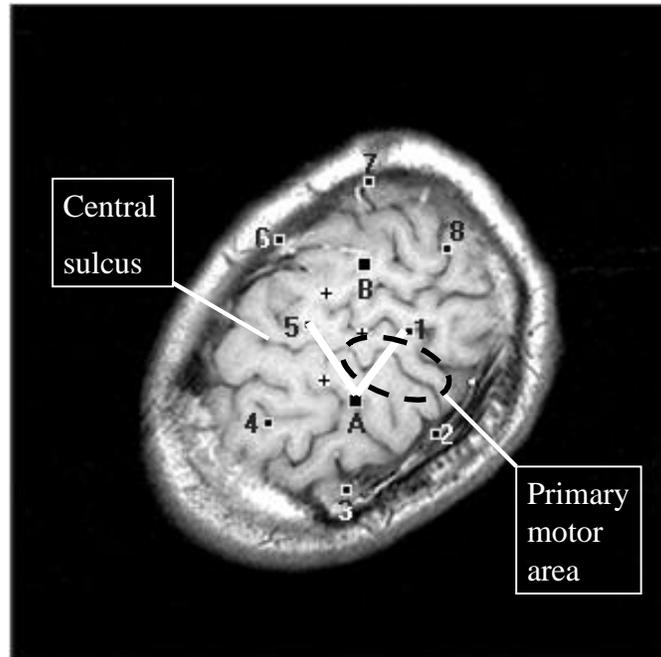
Orientation of the optical probe relative to the middle MRI slice. Numbers indicate source locations, letters – detectors. Light channels A5 and A1 cross the central sulcus in the primary motor area
